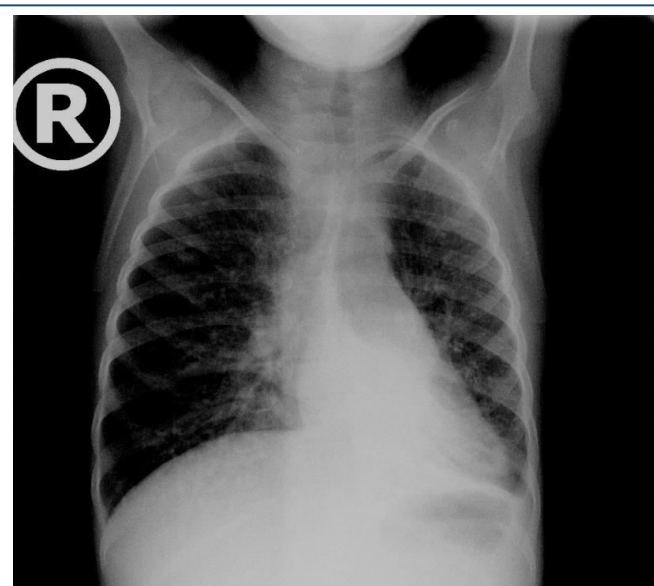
Second X-ray of the lung (age 7 years and 4 months) – more notable fibrosis changes bilaterally.
